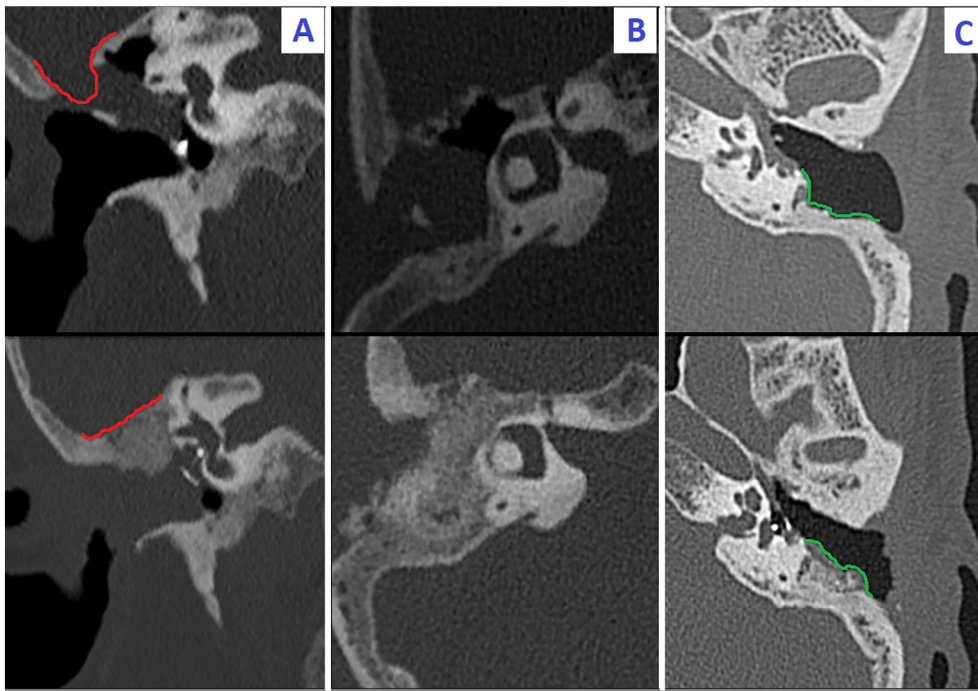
CT-scan appearance of middle ear before (above) and after (below) obliteration with 45S5 in 3 different cases.
